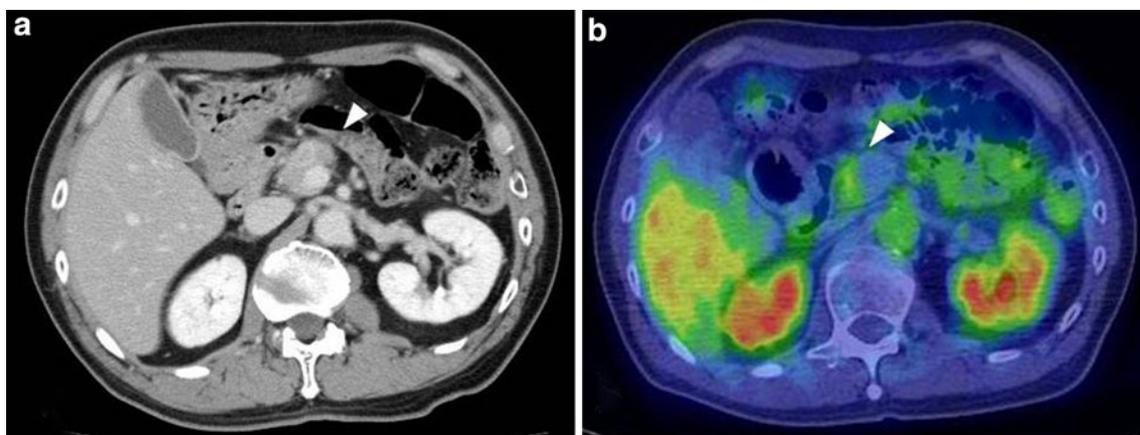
a Enhanced CT finding of the pancreas after four cycles of chemotherapy. b FDG-PET/CT finding of the pancreas after four cycles of chemotherapy
